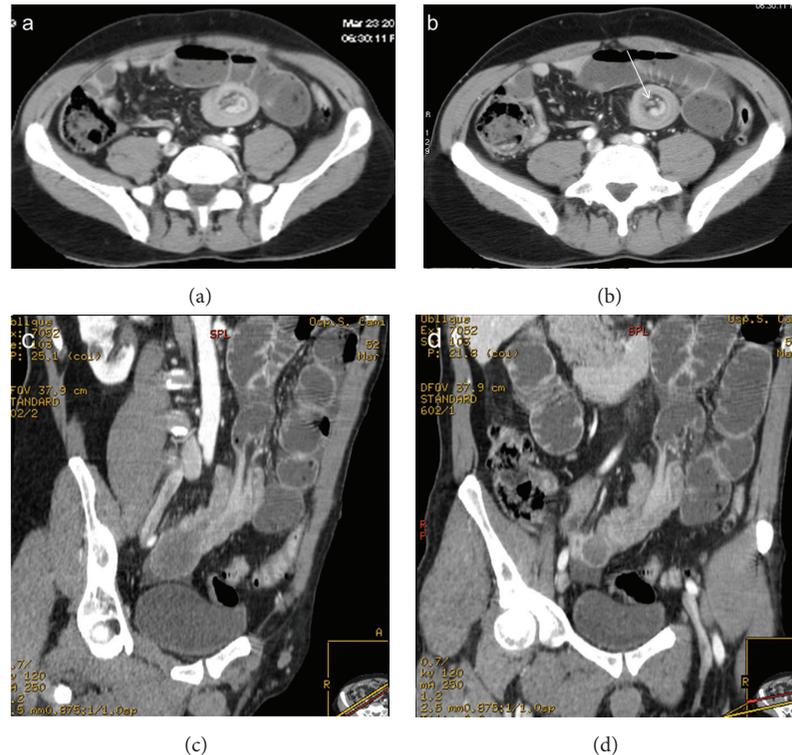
Enteroenteric intussusception. Axial CT images (a, b) demonstrate a round mass with “target” pattern and central hypodense area of mesenteric fat in which vessels are seen as linear enhanced structures (arrow). Oblique CT reformatted images (c, d) oriented parallel to the longitudinal axis of the intussusception depict intussusception as a large “sausage-shaped” mass, showing length of involvement. Gas-fluid levels in the dilated proximal loops are signs of small bowel obstruction.
